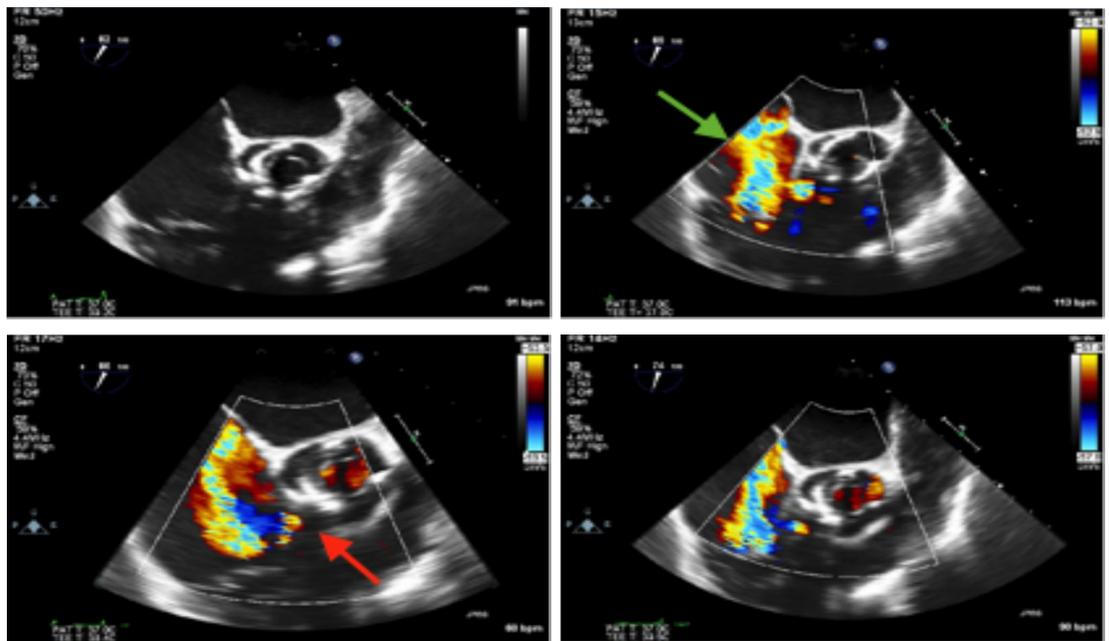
Transoesophageal echocardiography demonstrating Severe TR and an Aorta-to-Right atrium fistula.
